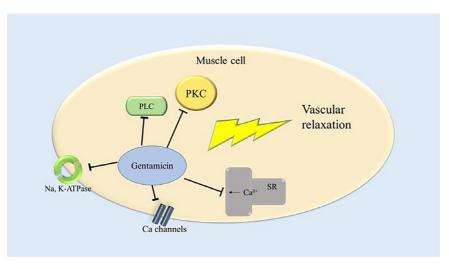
Aminoglycoside (gentamicin)-induced vascular relaxation modulation with low-frequency ultrasound. PKC = protein kinase C; PLC = phospholipase C; SR = sarcoplasmic reticulum.
